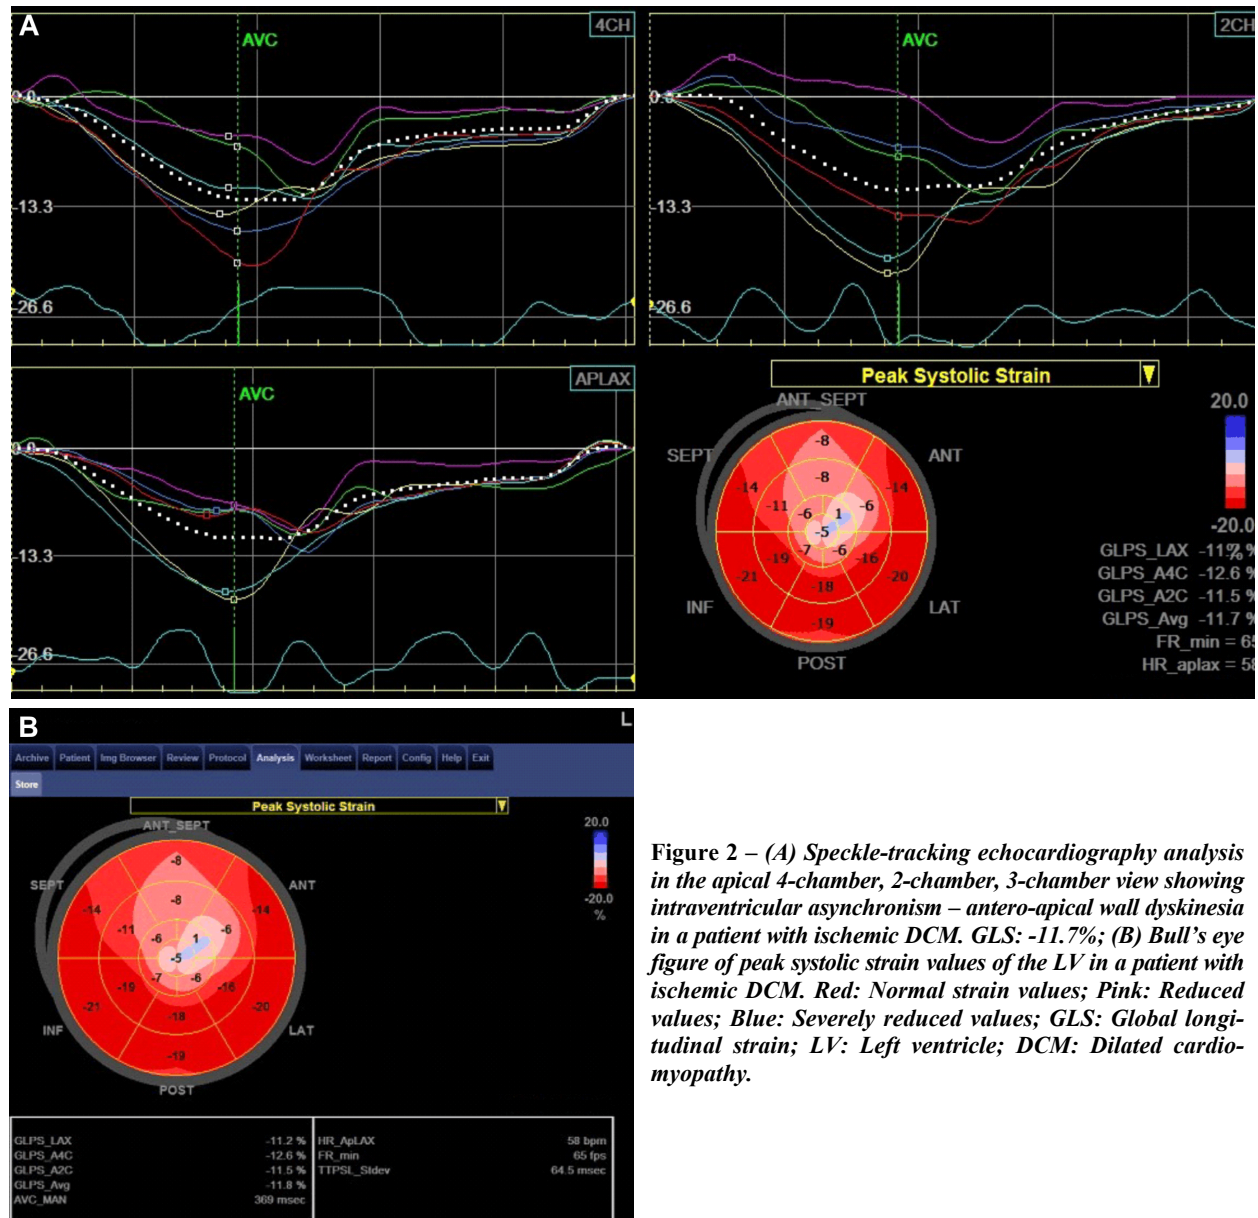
(A) Speckle-tracking echocardiography analysis in the apical 4-chamber, 2-chamber, 3-chamber view showing intraventricular asynchronism – antero-apical wall dyskinesia in a patient with ischemic DCM. GLS: -11.7%; (B) Bull's eye figure of peak systolic strain values of the LV in a patient with ischemic DCM. Red: Normal strain values; Pink: Reduced values; Blue: Severely reduced values; GLS: Global longitudinal strain; LV: Left ventricle; DCM: Dilated cardiomyopathy.
